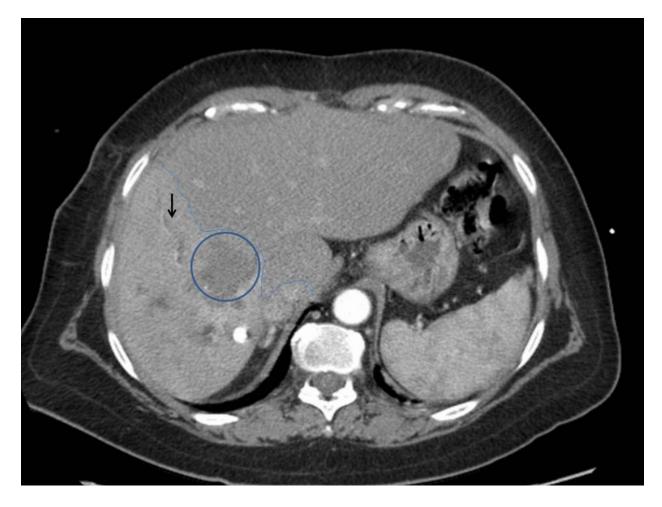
Post-contrast axial CT image showing nodular thickening of the margin of a treated lesion (black arrow), in keeping with recurrence
